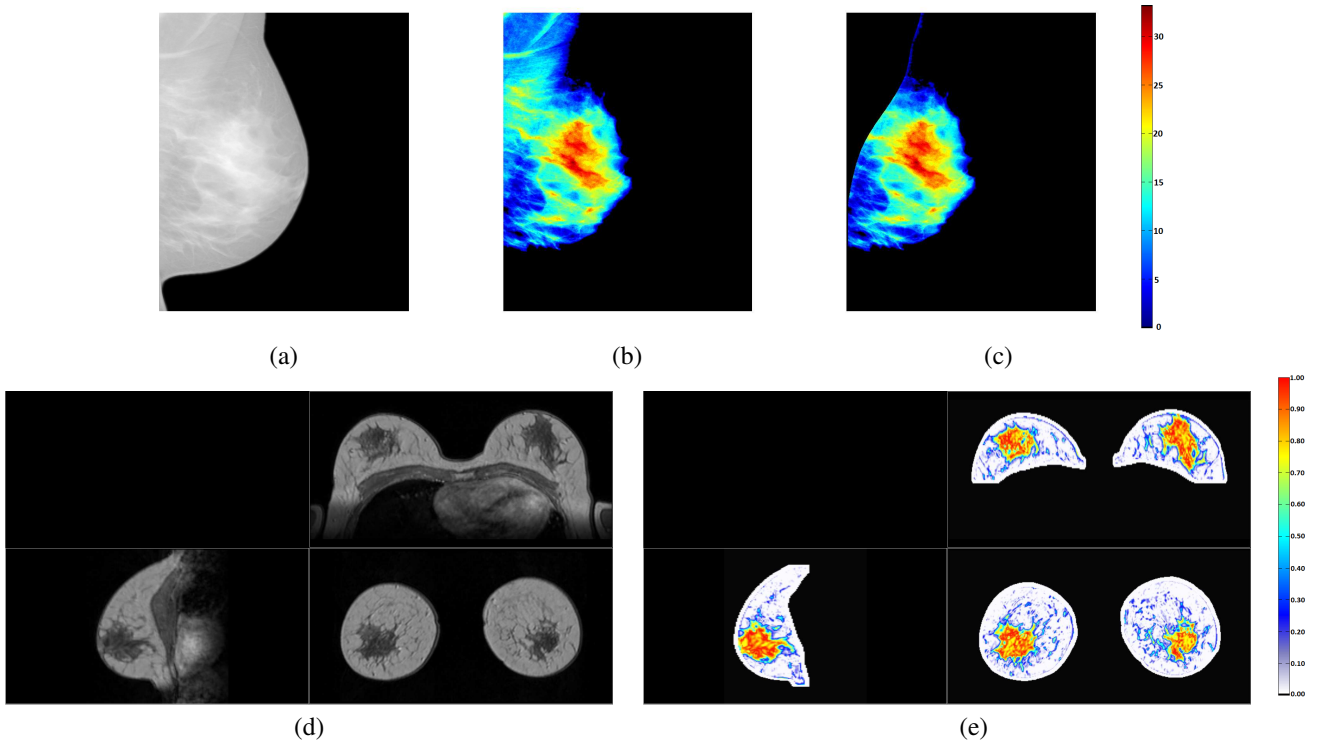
The first row shows (a) the mammogram and its corresponding density map (b) with and (c) without pectoral muscle. The colors represent the thickness of glandular tissue in millimeters (attached bar). The second row shows (d) the MRI and (e) the corresponding probabilistic segmentation of the glandular tissue. As in the mammographic density map, the blue color represents a low likelihood of belonging to the glandular tissue class while the highest probability is displayed in red. The white area represents the breast mask (attached bar).
